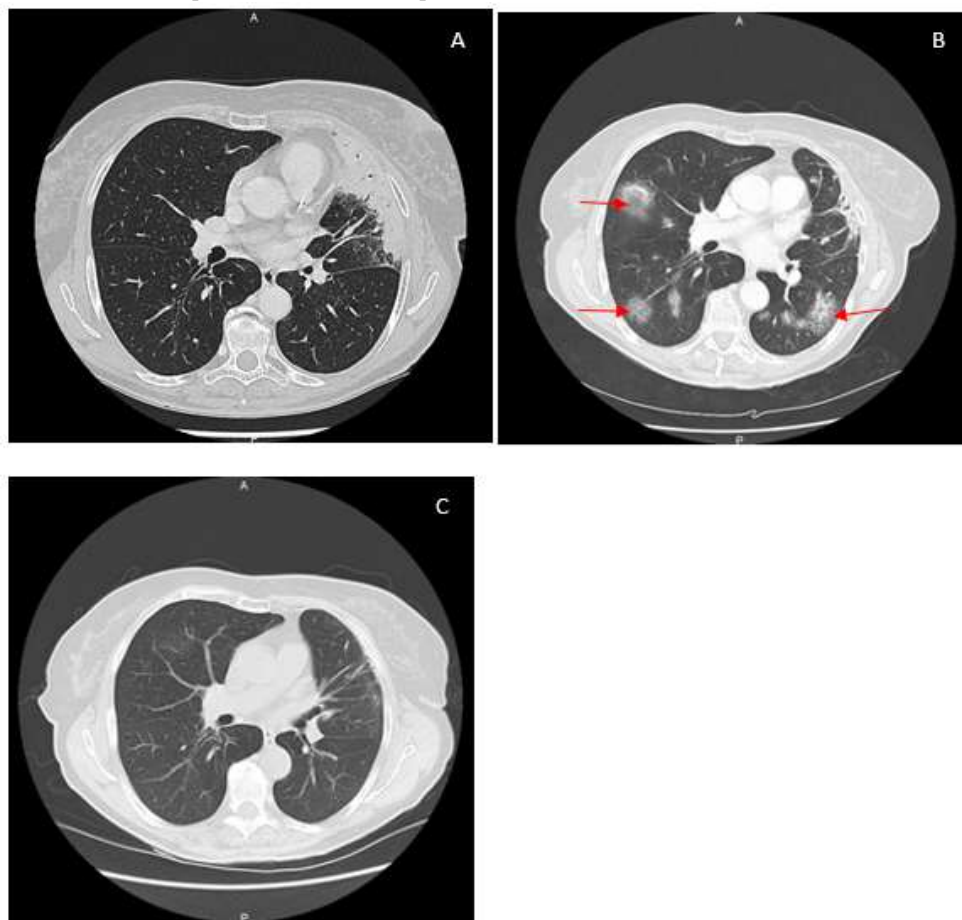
Chest computed tomography after radiotherapy three months (A), six months (B), eleven months (C)
